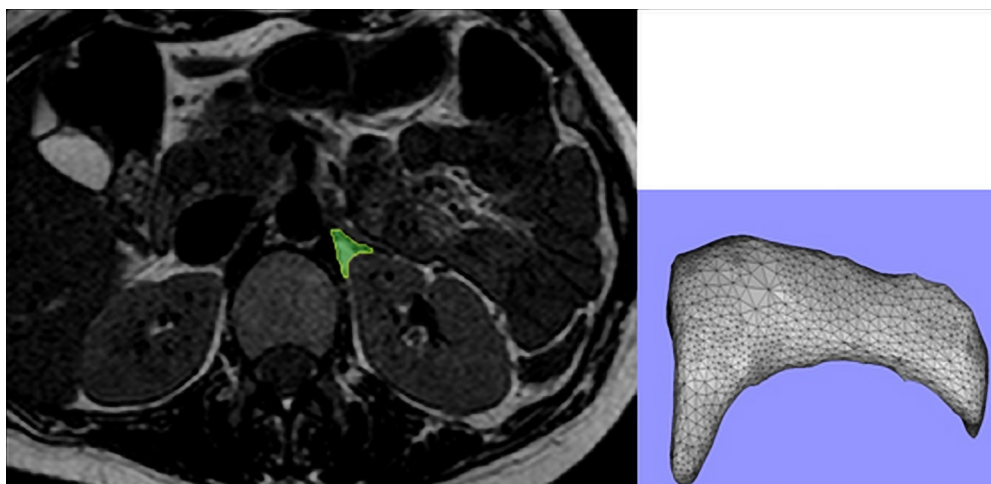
Each adrenal gland was manually traced on axial slice of T1-weighted MR sequence. A segmentation process was performed in order to use images for 3D reconstruction and was converted to a 3D mesh model using an adapted marching cubes algorithm.
